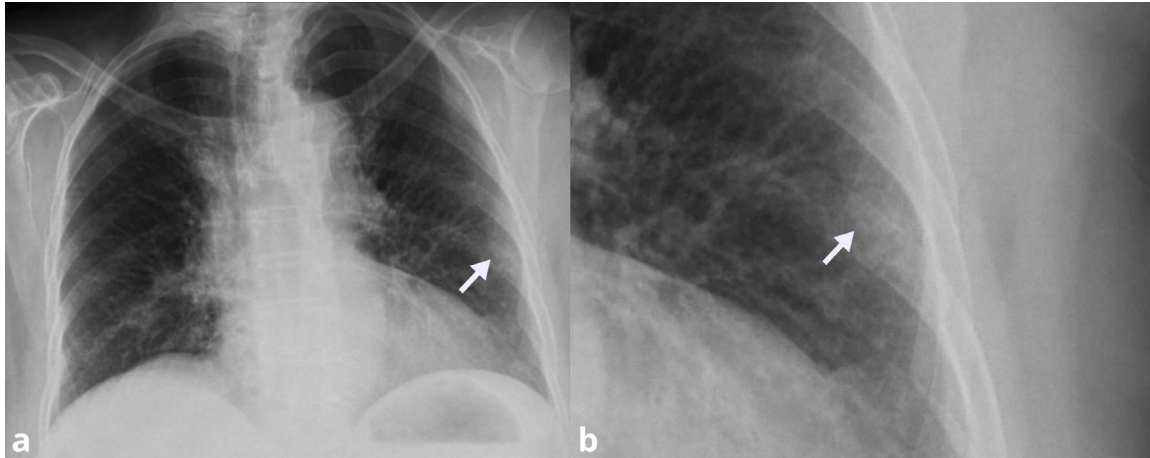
a. Chest X-ray shows nodular opacity under the left scapula (arrow). b. In the magnified image of the same radiograph, the ossicle, which can be confused with the pulmonary nodule, is observed more clearly.
